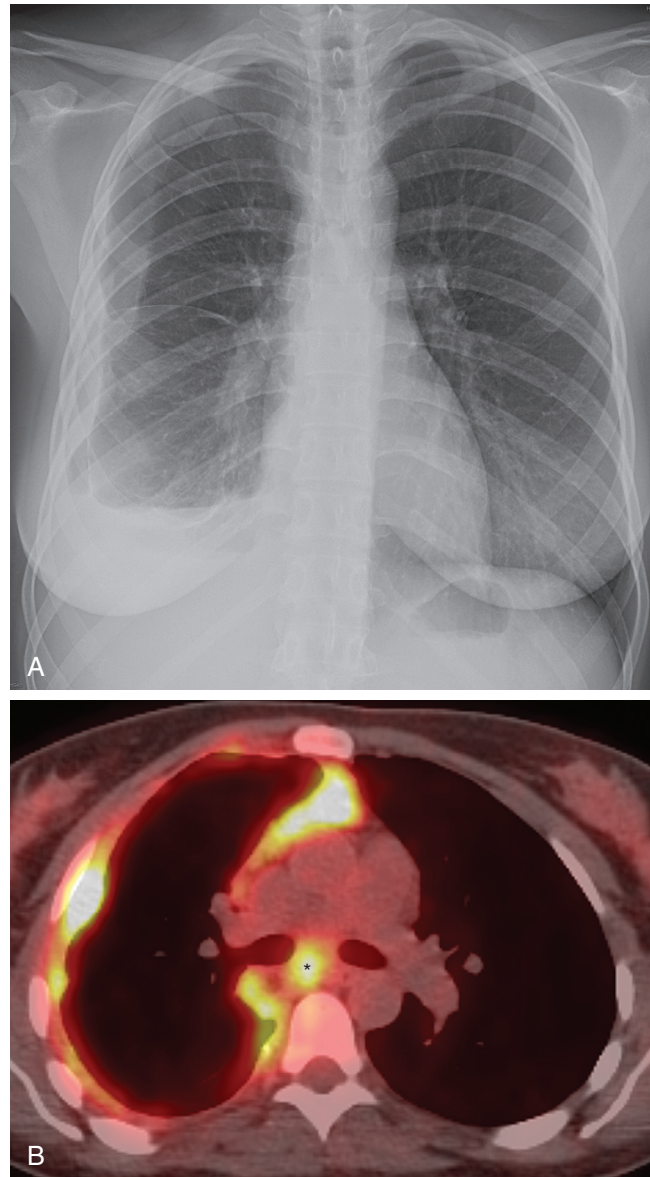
■ Malignant pleural mesothelioma. A, Posteroanterior chest radiograph shows moderate right pleural effusion and lobularity of the pleura. B, Axial fused positron emission tomography-computed tomography shows increased [¹⁸F] fluorodeoxyglucose uptake in pleural masses and focal uptake in subcarinal node (*asterisk*). Biopsy of subcarinal node revealed metastatic pleural mesothelioma, precluding extrapleural pneumonectomy.
